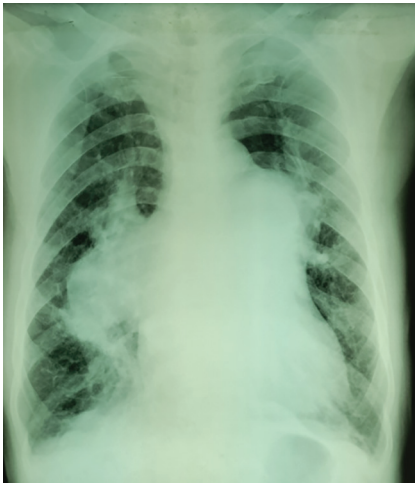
Chest radiograph image of the patient showing well-defined, convex, dense right hilum and prominent pulmonary bay
